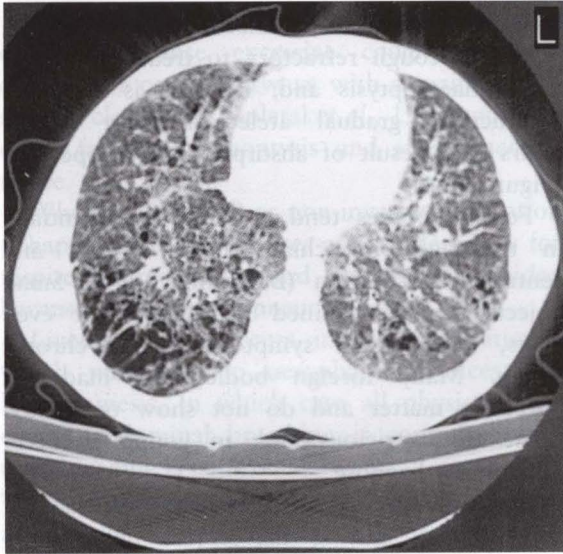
CT scan of Mr MB.
